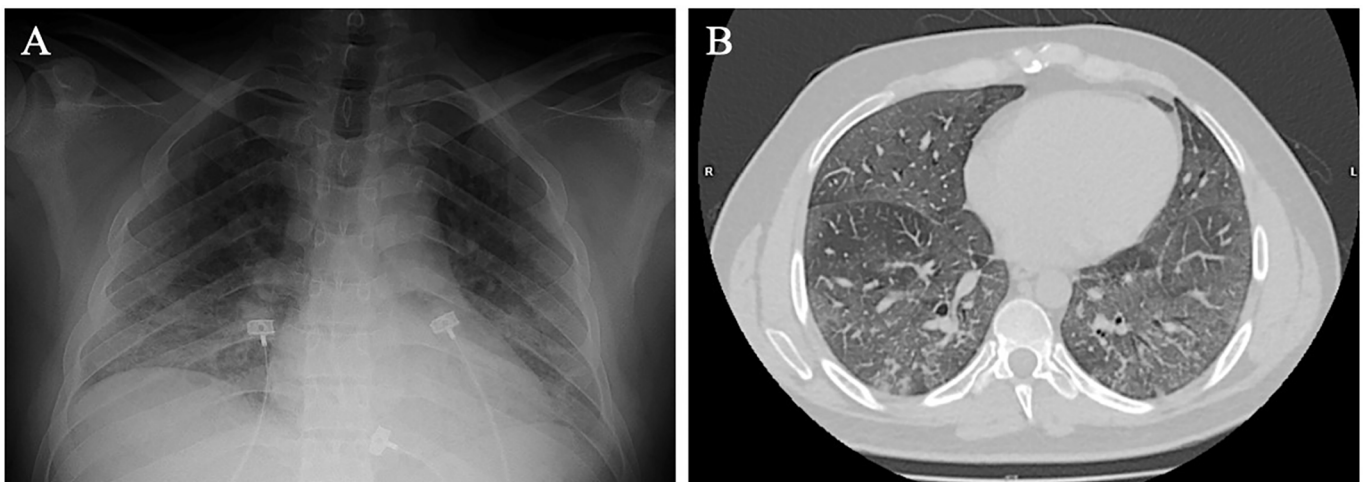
Chest radiography (A) and computed tomography (B) at admission.
